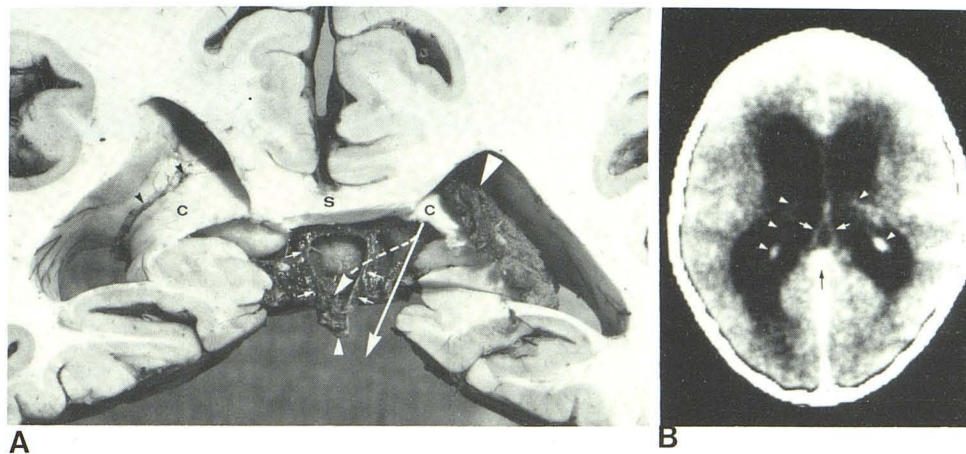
Relations among crura, choroid plexi, and internal cerebral veins. A, Coronal section through atria from behind, after partial resection of splenium (S). On right side, choroid plexus (*large white arrowhead*) partly overlaps crus (C) of right fornix. Resection of left choroid plexus exposes full crus (C) and origin of choroid plexus from tela choroidea at lateral edge of fornix (*black arrowheads*). Two internal cerebral veins (*short white arrows*) join to form vein of Galen (*small white arrowhead*) in midline. Unilateral atrial diverticulum that extends infratentorially would follow course of long white arrow to displace choroid plexus laterally and internal cerebral veins contralaterally, widening gap between them. Dashed sidearm of long white arrow indicates infrequent medial extension of diverticulum over internal cerebral vein into cistern of velum interpositum. B, Contrast-enhanced axial CT in hydrocephalic patient without pulsion diverticulum. Two internal cerebral veins (*white arrows*), vein of Galen (*black arrow*), and symmetrical glomera and bodies of choroid plexi (*arrowheads*). Distance between glomera and internal cerebral veins estimates sizes and positions of crura of fornices.
